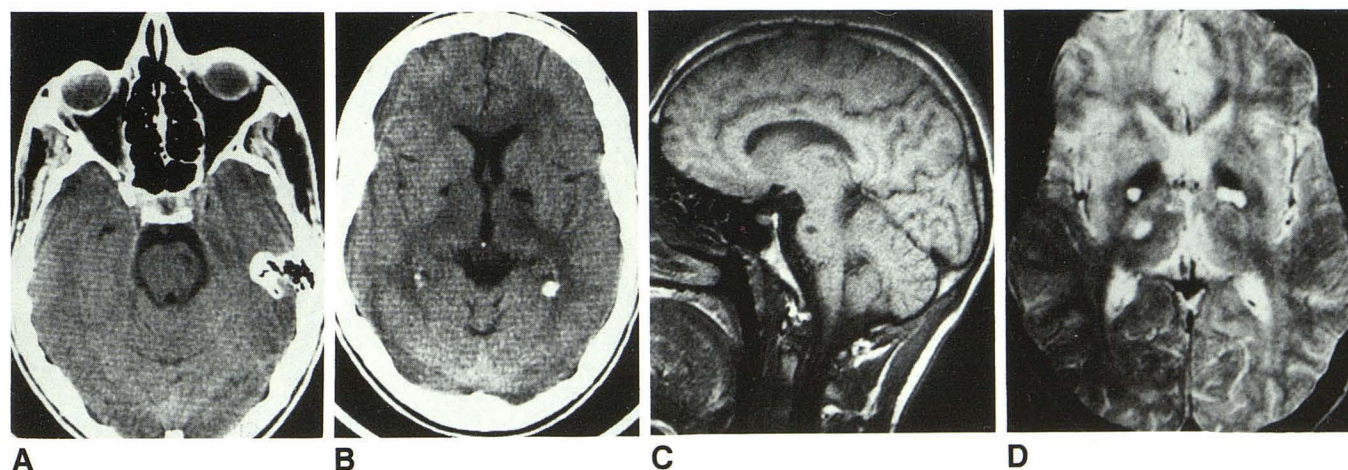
A and B, CT scans show lacunar infarcts in left pons (A) and in both pallidal nuclei and adjacent left internal capsule (B). C, T1-weighted sagittal MR image (350/30) shows lacunar infarcts in pons and corpus callosum. D, T2-weighted MR image (2100/100) shows multiple lacunes in both basal ganglia, left thalamus, and posterior limb of right internal capsule.
